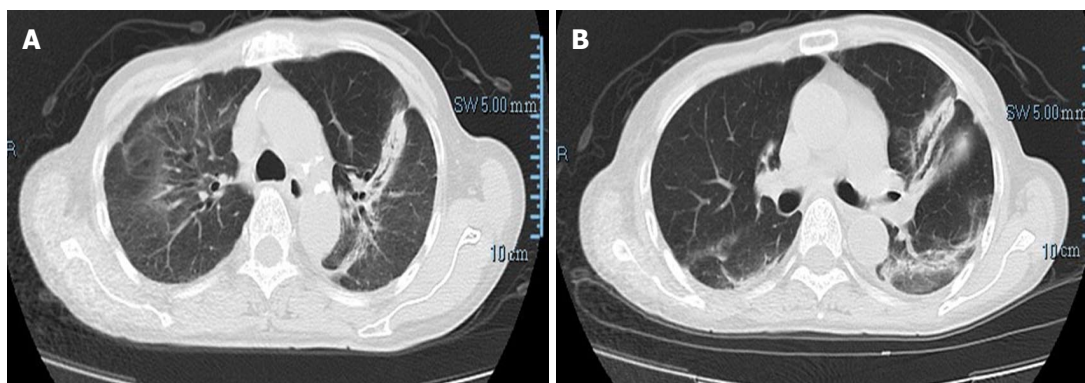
Repeat chest computed tomography scan after 1 wk steroid treatment showed significant improvement, and bilateral lesions resolved gradually.
